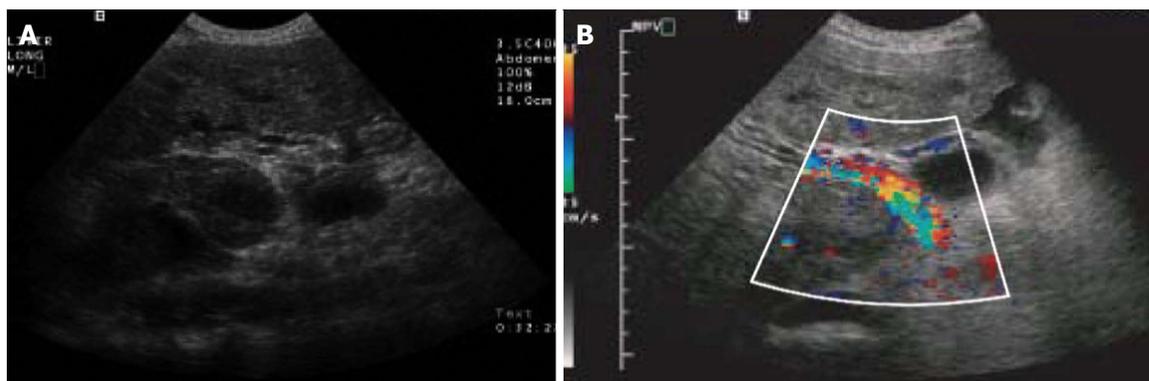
Colour Doppler ultrasound of the liver. A: Transverse sonogram shows portal vein thrombus; B: Transverse colour Doppler sonogram of the right upper quadrant shows heterogeneous flow within the tumour thrombus^[47].
